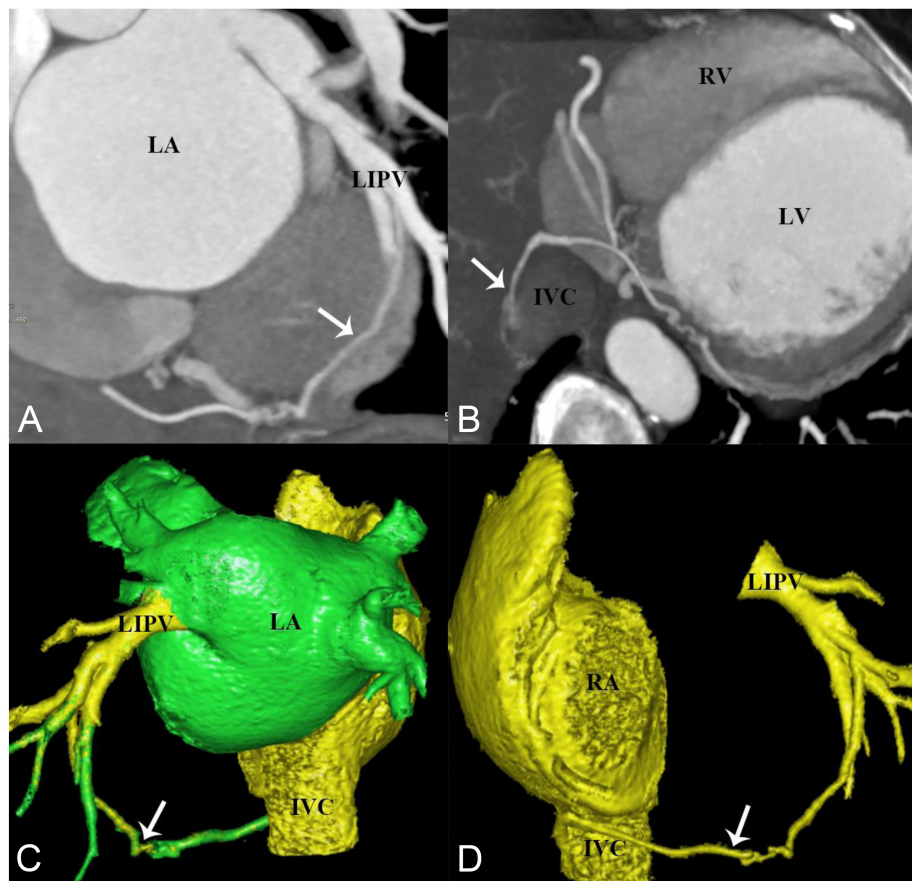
The maximum intensity projection of CTA and image shows a LACV connecting the LIPV to the inferior vena cava (IVC). (C and D) The VR CTA image intuitively shows an anomalous venous channel connecting the LIPV to the IVC. CTA, computed tomography angiography; IVC, inferior vena cava; LA, left atrium; LACV, levoatrial cardinal vein; LIPV, left inferior pulmonary vein; LV, left ventricle; RA, right atrium; RV, right ventricle.
